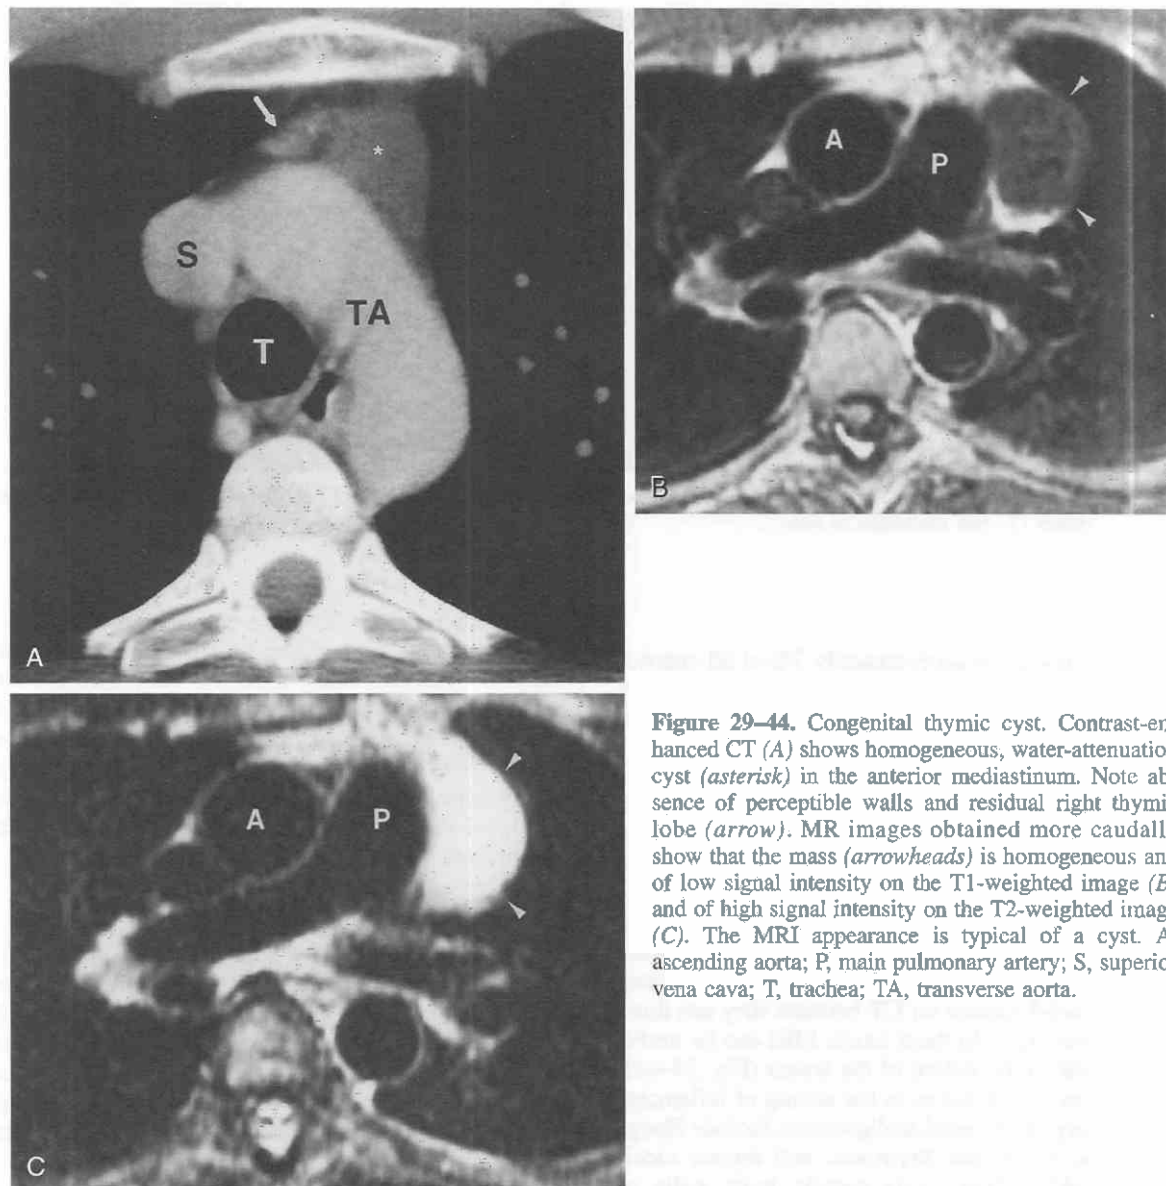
Congenital thymic cyst. Contrast-enhanced CT (A) shows homogeneous, water-attenuation cyst (asterisk) in the anterior mediastinum. Note absence of perceptible walls and residual right thymic lobe (arrow). MR images obtained more caudally show that the mass (arrowheads) is homogeneous and of low signal intensity on the T1-weighted image (B) and of high signal intensity on the T2-weighted image (C). The MRI appearance is typical of a cyst. A, ascending aorta; P, main pulmonary artery; S, superior vena cava; T, trachea; TA, transverse aorta.
